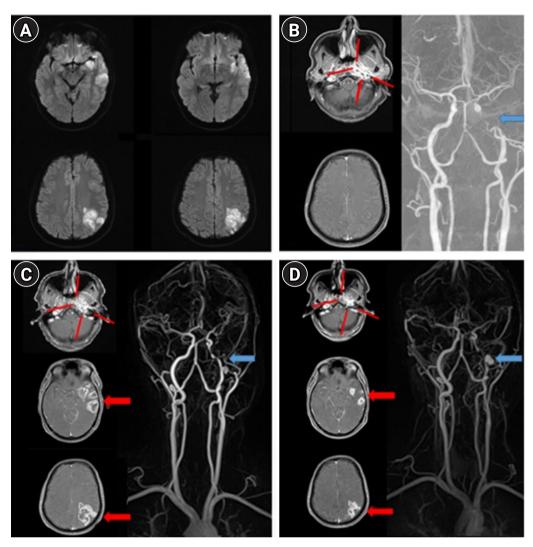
Brain magnetic resonance imaging (MRI) and computed tomography angiography (CTA) findings at admission (A, B), at 2 weeks of hospitalization after the onset of endogenous endophthalmitis (C), and at 8 weeks of hospitalization after completion of the antibiotic treatment (D). (A) Baseline MRI revealed multiple embolic infarctions on diffusion weighted image sequence in the region of the left middle cerebral artery. (B) Baseline MRI revealed an increased gadolinium enhancement in the left infratemporal fossa and skull base (red lines) and sulcal enhancement in the hemispheres (left), and baseline CTA (right) revealed a narrowing in the left petrous portion of the internal carotid artery (ICA; blue arrow), compatible with osteomyelitis due to the extension of a deep neck infection into the ICA. (C) Follow-up MRI revealed an increased enhancement in the left infratemporal fossa and skull base (red lines) and newly developed ring enhancement in the infarct area (suspicious of brain abscess formation; red arrows), and follow-up magnetic resonance angiography (MRA) revealed an interval improvement of the left distal ICA stenosis with a newly developed aneurysmal formation (mycotic aneurysm, blue arrow). (D) Follow-up MRI revealed an increased size of the aneurysm in the ICA (blue arrow).
